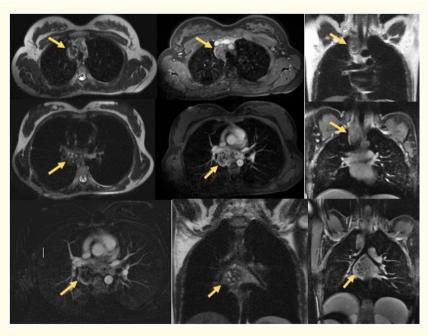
Axial and coronal view T2W and T1 C+ FatSat MRI images: Two masses of the posterior mediastinum (Arrow) containing a multilocular cystic components with thick fibrous septa and late enhancement of the walls and septas after gadolinium administration.
